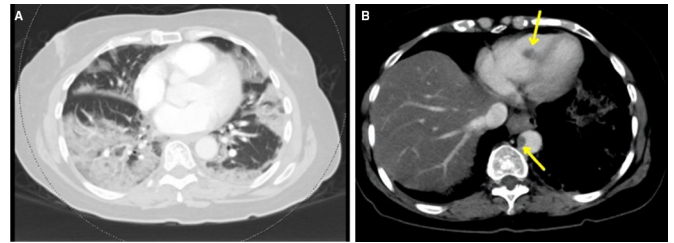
CT chest pulmonary angiogram (axial view) (A) showing bilateral peripheral ground-glass opacities with intralobular septal lines and areas of denser consolidation (B) showing an area of hypoattenuating focus within the right ventricular apex as well as thoracic aorta concerning for thrombi.
